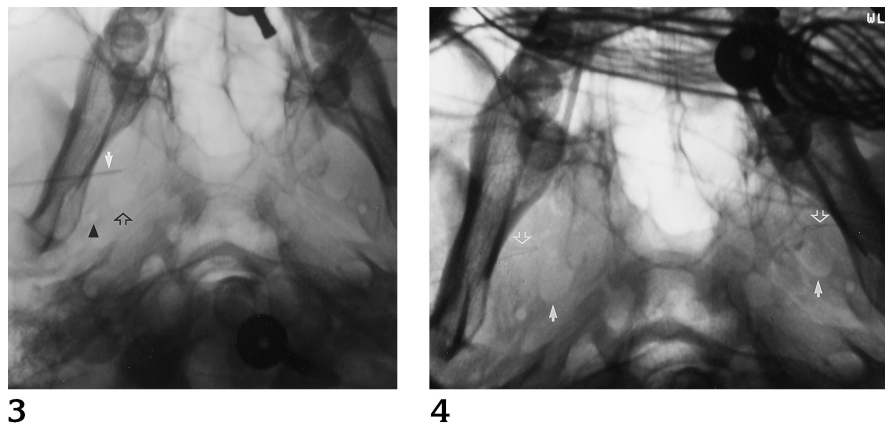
Submentovertex radiograph shows the normal relationship of the foramen ovale (open arrow) to the foramen spinosum (arrowhead). The electrode/needle system (solid arrow) is positioned anterior and slightly lateral to the foramen ovale.
